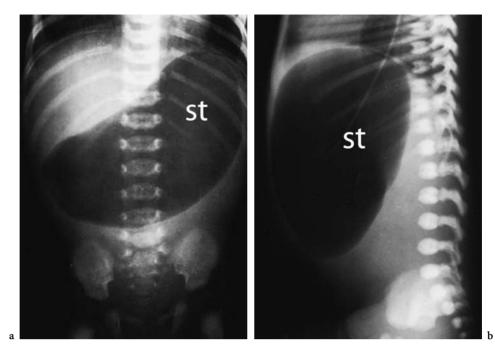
Pyloric atresia. Anteroposterior (a) and lateral (b) plain abdominal radiograph in a newborn infant that shows distension of the stomach (*st*) and absence of air in the small bowel and colon, resulting in the characteristic "single bubble" image
